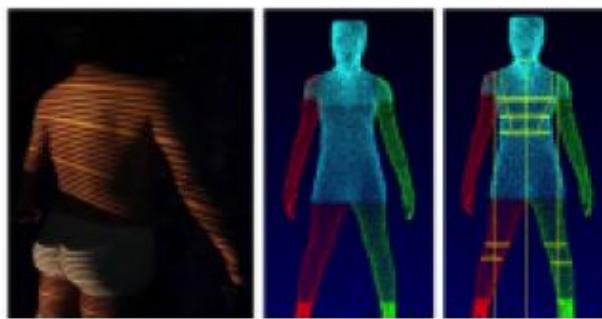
Computed tomography body segment .
